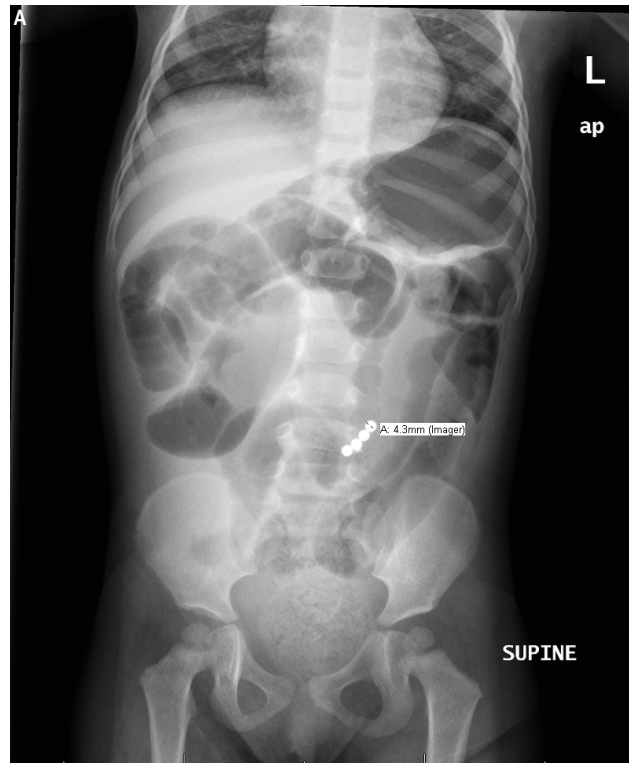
A. Abdominal radiograph reveals 4 small adjacent radiopaque foreign bodies in the midabdomen.
